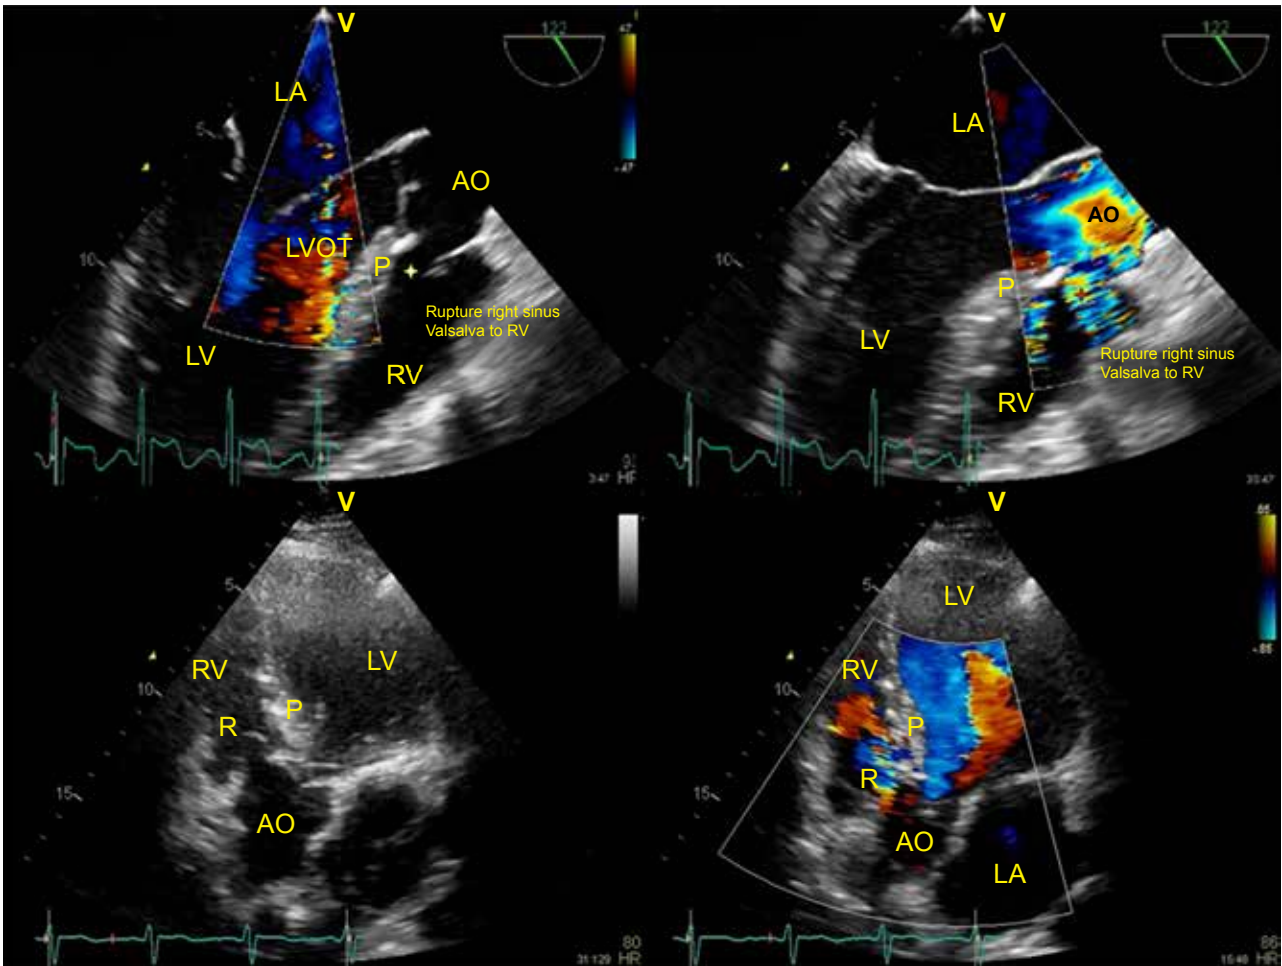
Echocardiographic images depicting a right coronary sinus to right ventricle communication through a residual ventricular septal defect. Ao – aorta; LA – left atrium; LV – left ventricle; LVOT – left ventricular outflow tract; RV – right ventricle; P – ventricular septal defect patch; R – rupture.
